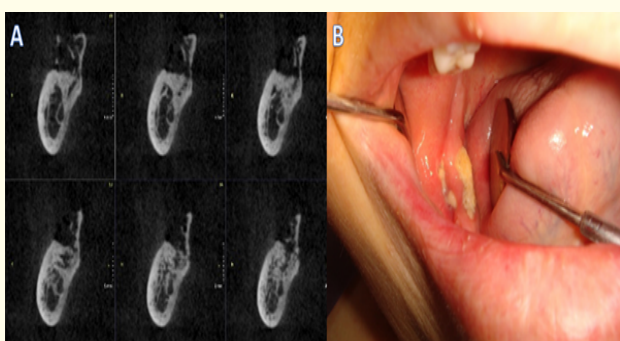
CBCT-Cross section images of the patient's right molar site of the mandible. Note the destruction and osteosclerosis at the bone.
